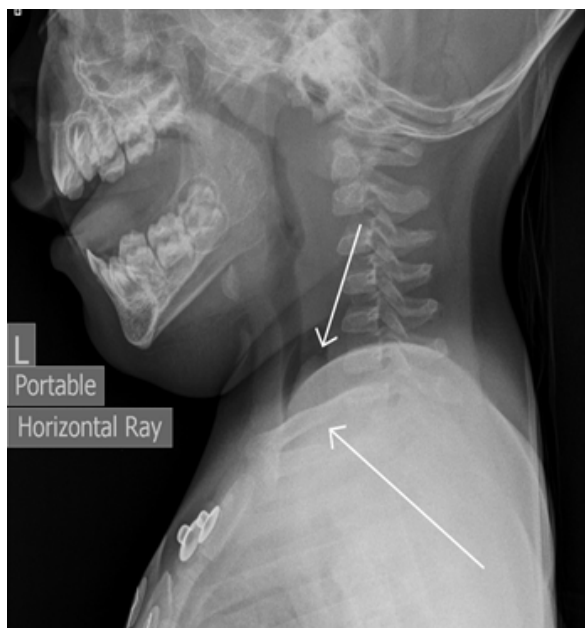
Lateral neck X-ray showing a food bolus (marked in arrows) in oesophagus with compression of trachea
